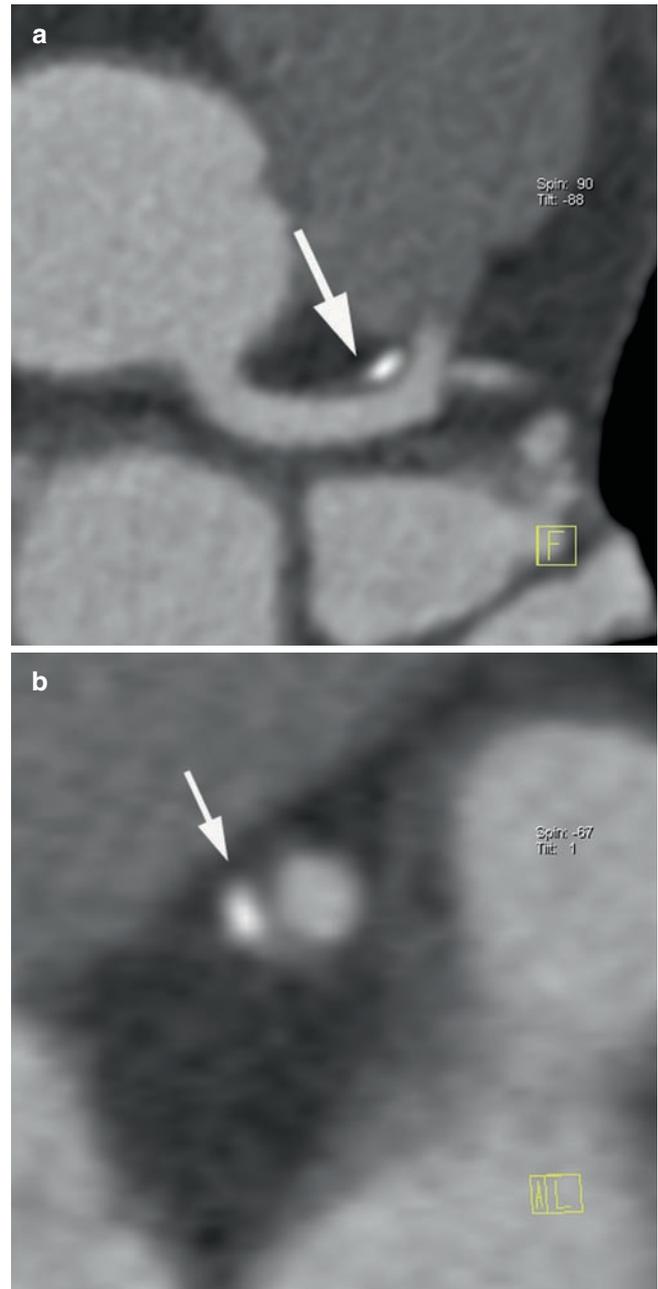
Visualization of partly calcified plaque by coronary CT angiography. (a) A transaxial image shows a partly calcified, partly non-calcified plaque at the distal left main and very proximal left anterior descending coronary artery. (b) Cross-sectional view of the same lesion. Contrast-enhanced lumen and an eccentric plaque with non-calcified and calcified components (*arrow*) can be appreciated
